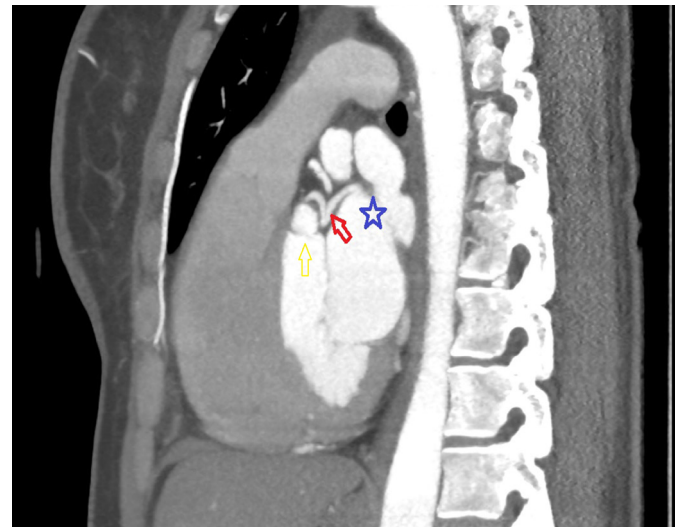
Case 2. Sagittal MIP CT image. Blue star: LAA; red arrow: GCV; yellow arrow: left ventricular outflow tract
